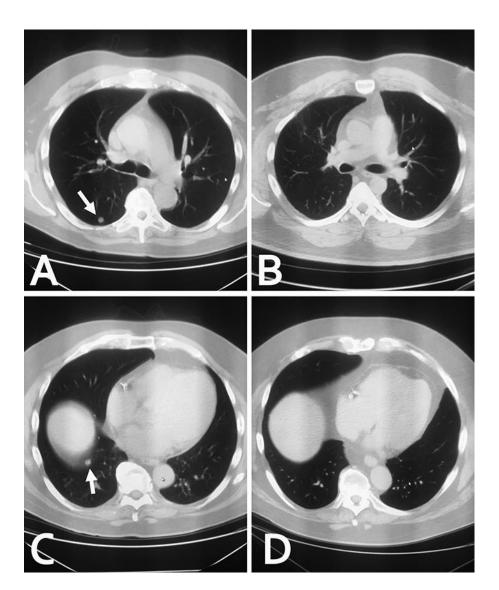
Chest CT scans demonstrated two noncalcified 8.0-mm pulmonary nodules in the right lower lobe of the lung prior to the CT-guided fine needle biopsy (A, C) (arrows) and resolution of the pulmonary nodules 13 weeks following the biopsy (B, D).
